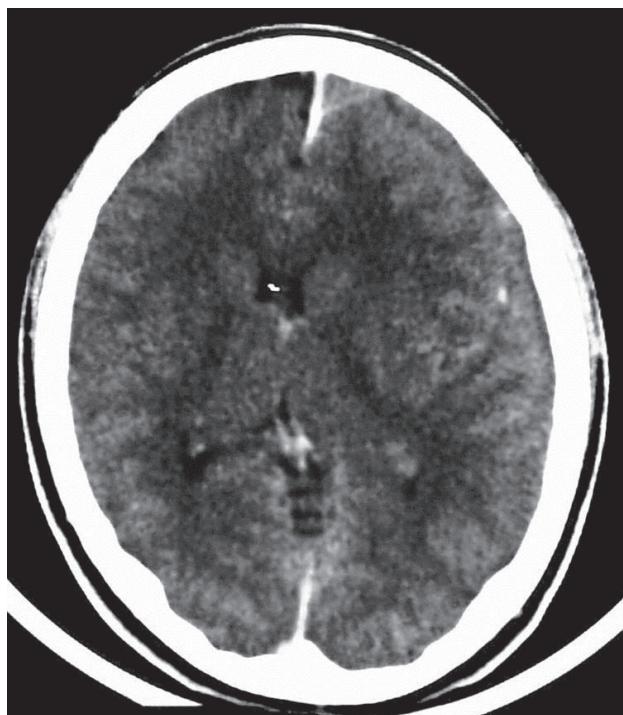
Brain CT Scan after IV contrast.
